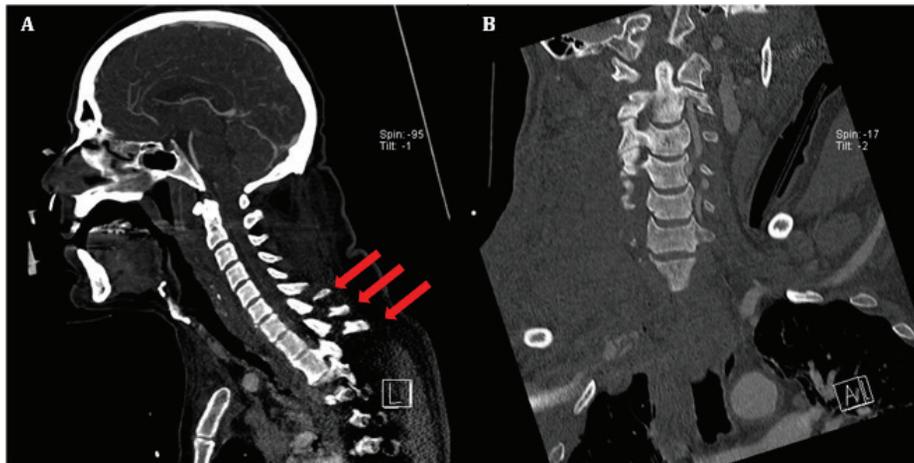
Computed tomography Angiography (CTA): sagittal view demonstrating multiple spinous process fractures in the cervico-thoracic junction (A) and absent perfusion of the right vertebral artery in coronal view (B).
